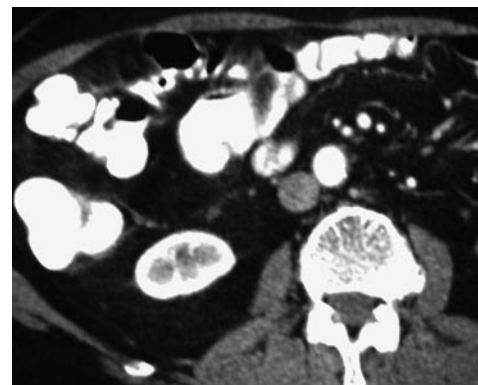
Computed tomographic scan obtained 6 mo after the treatment show a normal colonic wall thickness.
